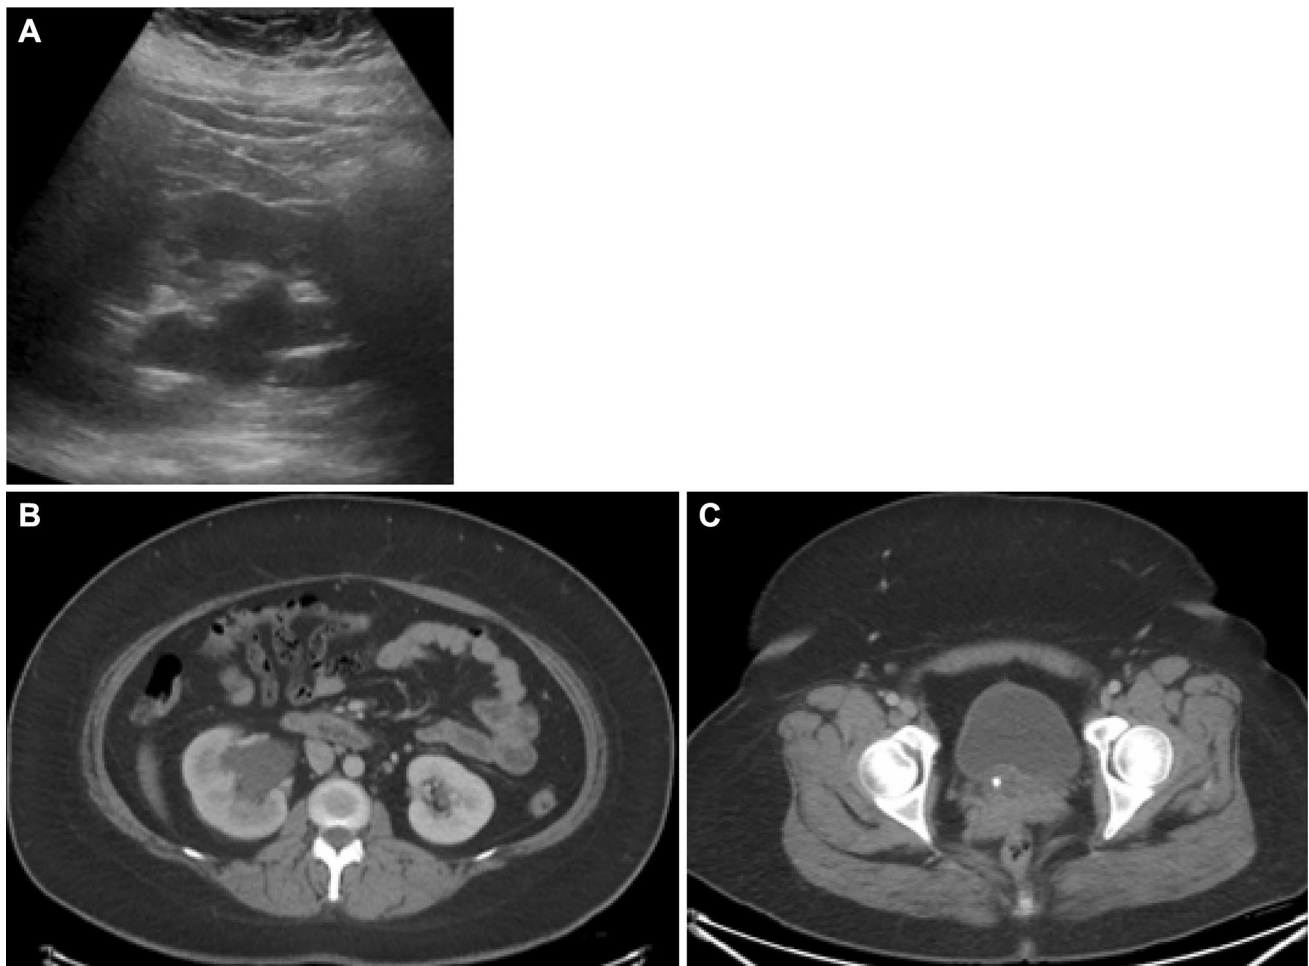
28-year-old-female presented with right-sided abdominal pain. Transabdominal image from initial TVUS (A) demonstrates moderate right-sided hydronephrosis. Subsequent CT confirmed this, but
